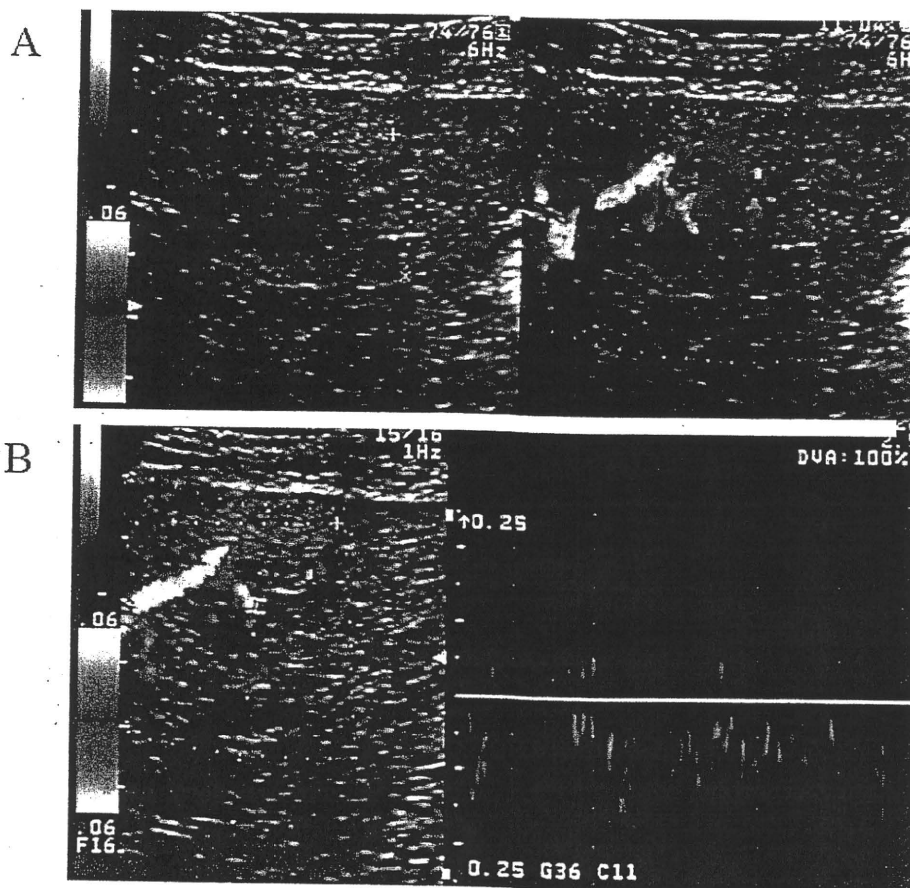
Color Doppler examination. A: Color Doppler image showed an artery running along the margin of nodule, with a branch turning toward the center of the nodule. B: Fast Fourier transformation indistinctly demonstrated an arterial pulsatile wave in this branched artery.
